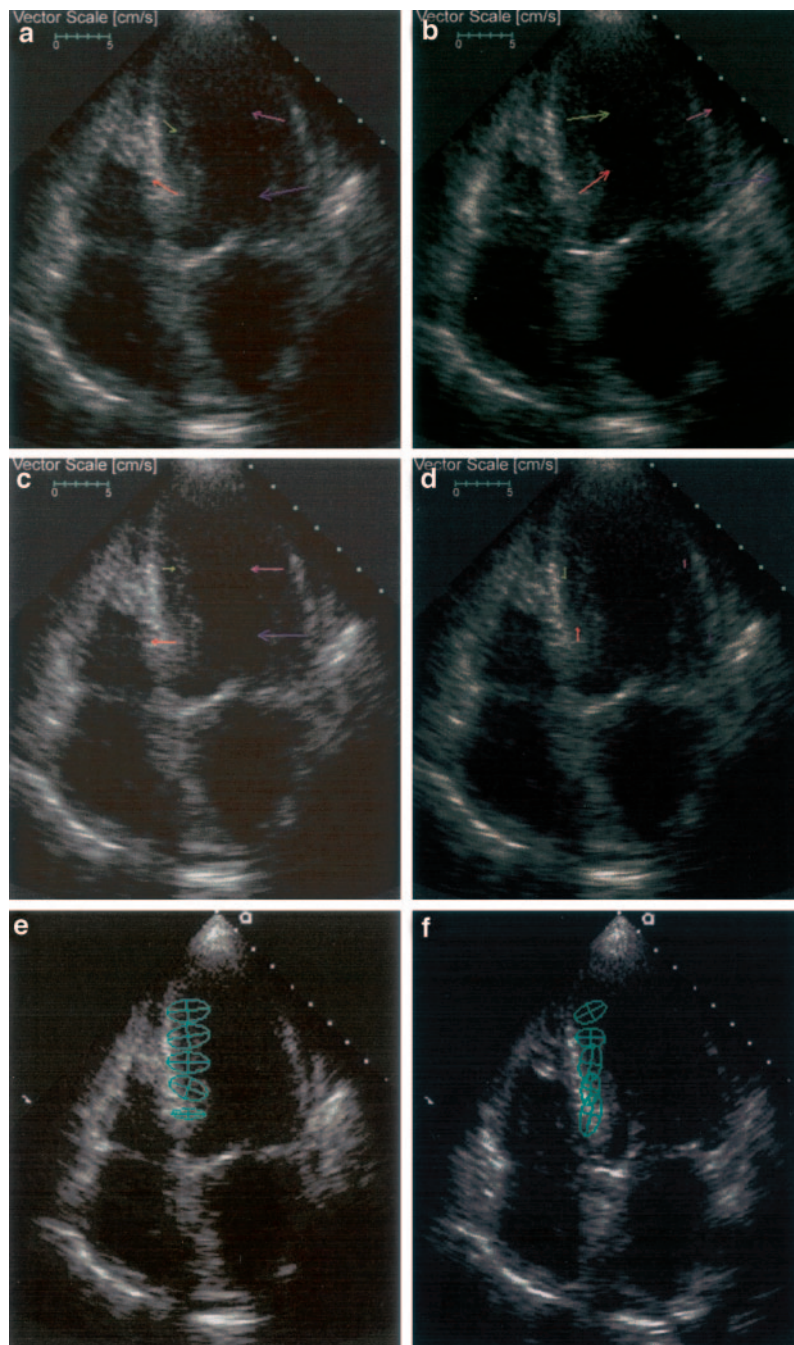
Case study in apical 4-chamber view. Multiscale motion mapping indicates paradoxical motion of interventricular septum (outward during systole [a], inward during diastole [b]). Separate analysis of transverse (c) and longitudinal (d) motion shows impaired longitudinal velocities but normal transverse velocities (lateral wall) during systole. Despite paradoxical septal velocities, deformation imaging shows normal radial thickening with shortening along septum during systole (e), documenting normal contractility of septum, with reciprocal findings in diastole (f).
